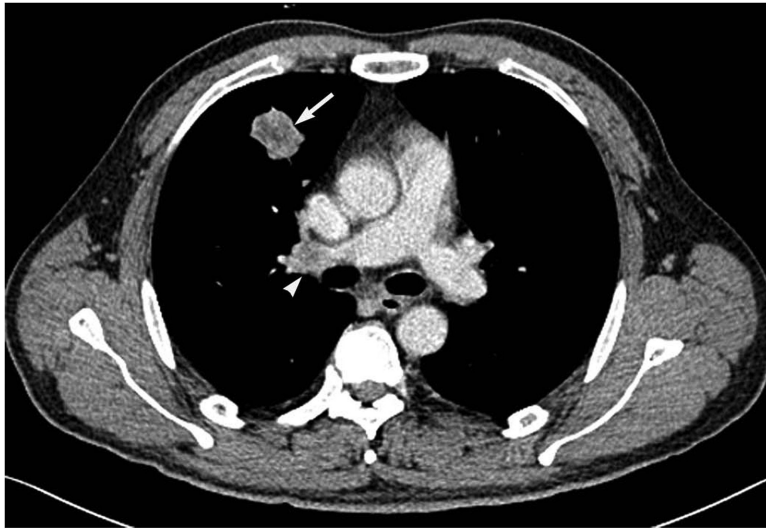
CT image of a 47-year-old man with a solid adenocarcinoma harboring *ALK* rearrangement shows a solid tumor (arrow) with lymphadenopathy (arrowhead).
